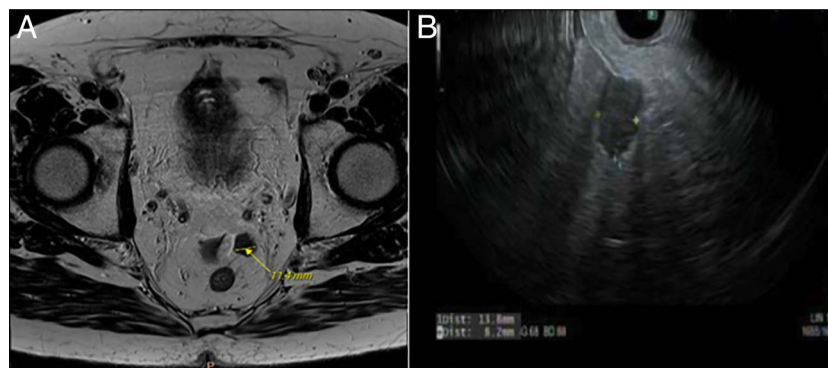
(A) Pelvic MRI with 1.1 cm left-sided perirectal lesion. (B) Endoscopic ultrasound (EUS) with 1.1 cm left-sided perirectal lesion.
